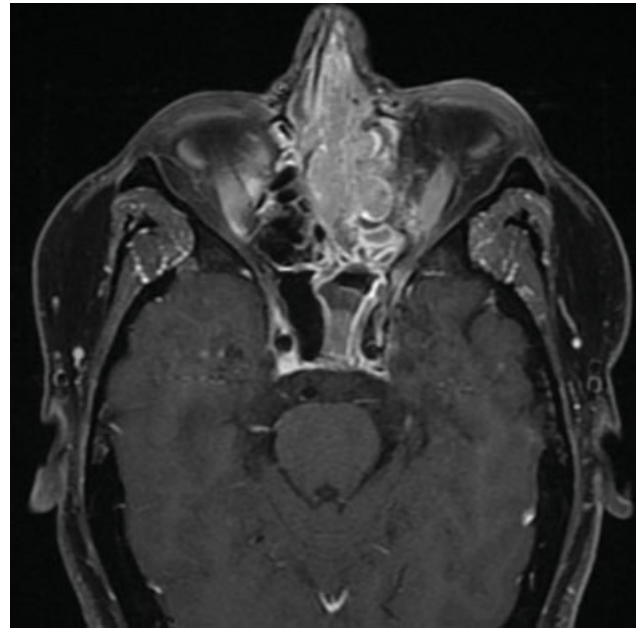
Preoperative MRI, axial view.
